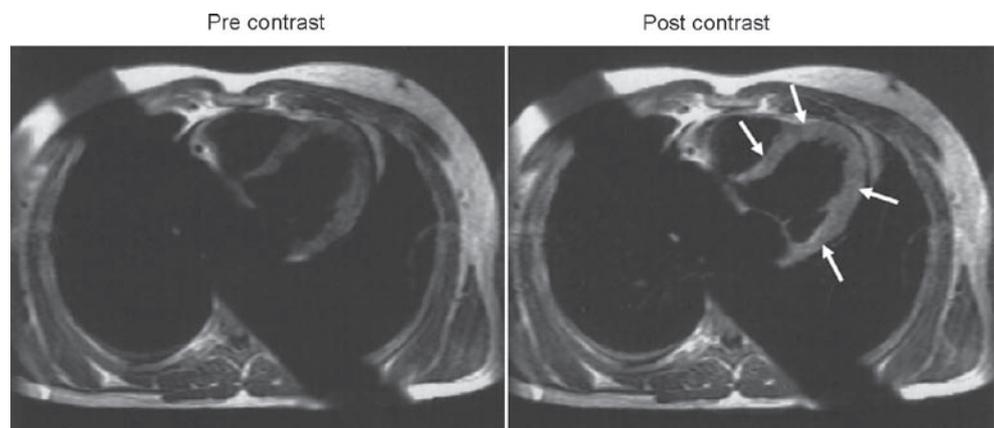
T1-weighted cross-sectional views at the mid-ventricular level of a patient with myocarditis. The *left panel* displays a view obtained before gadopentate dimeglumine (Gd-DTPA). The *right panel* depicts the same view after the administration of 0.1 mmole/kg Gd-DTPA. Note diffuse signal enhancement in the left ventricle. Reprinted with permission from Friedrich et al.⁹
